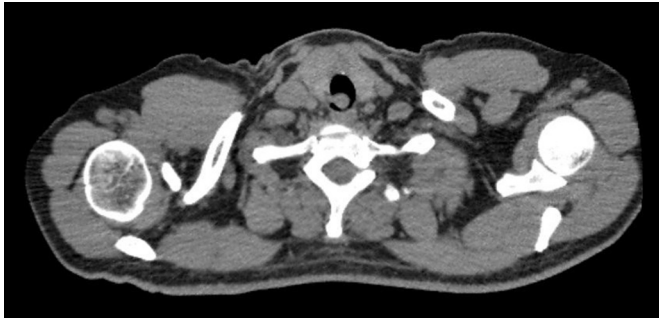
Axial CT image demonstrating partially occlusive, pedunculated tracheal lesion.
